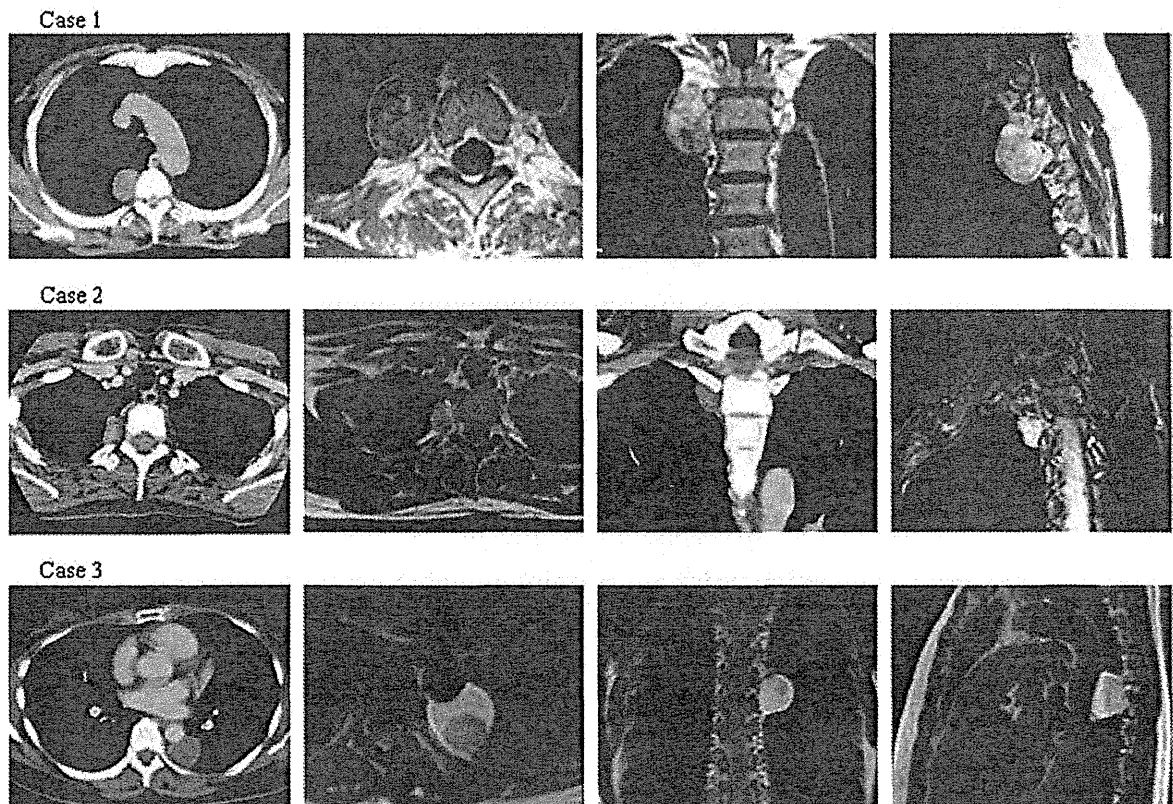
Chest computed tomography and magnetic resonance images showing the various posterior mediastinal tumors in 3 patients.
